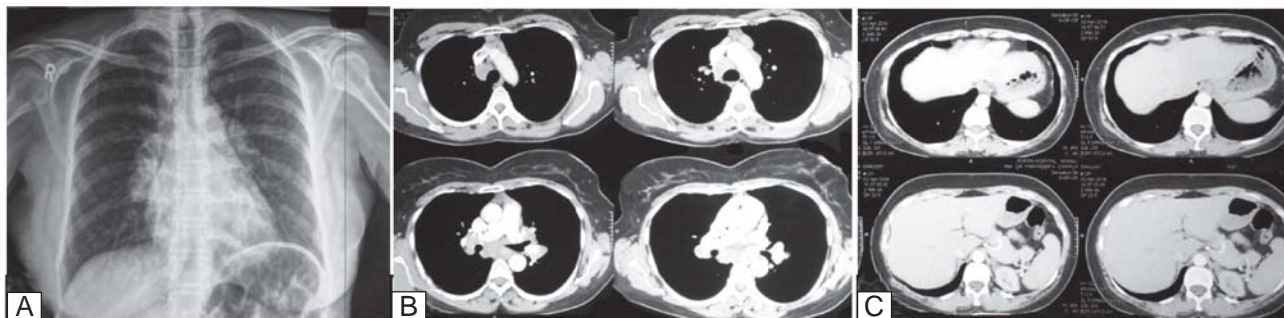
(A) Chest radiograph (postero-anterior view) showing bilateral hilar and right paratracheal lymphadenopathy with normal bilateral lung fields and clear costophrenic angles, (B and C) contrast-enhanced computed tomography of chest (axial view) showing enlarged hilar and mediastinal lymph nodes without necrosis. There is no evidence of pleural effusion or thickening.
